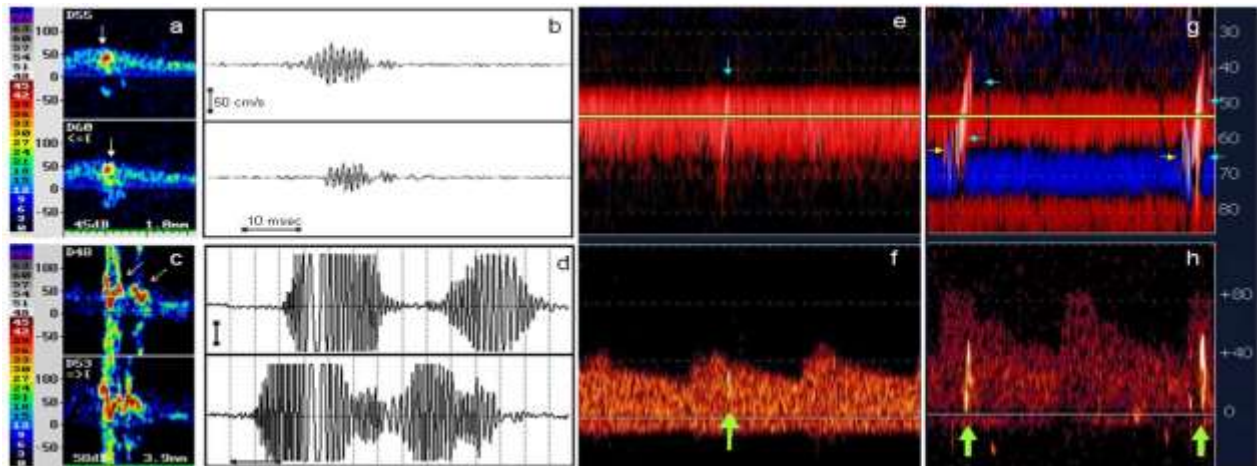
Typical sonogram (a) and time domain (b) appearance of a solid (formed, particulate) MES by dual gate technology. Signal duration and amplitude of this MES are lower than those of two gaseous (air) emboli documented on sonogram (c) and raw Doppler display (d). While a tail sign is associated with solid embolus, mirroring echoes are visible on the both side of the air emboli. Albeit frequency modulation is discernible for both type embolus, this is more exaggerated for aerogenic ones. A typical MCA solid MES signatures observed in a subject with critical ipsilateral ICA stenosis (where the MCA flow is significantly dampened) on M-mode (e, blue arrow) and corresponding single gate sonogram (f, yellow thick arrow). Two air emboli, seen on the M-mode display (g, blue arrow) and sonogram (h, thick green arrows), have brighter appearance compared to the solid ones. Of note, M-mode tracking indicates complex trajectory of MES in-transit: both are coming through TICA (blue track, blue arrows) and then entering into the MCA (red track, clue arrows) and later going distally.
